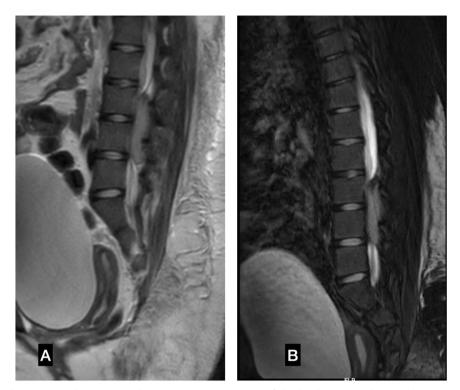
Radiographic findings. Sagittal T2W (A) and mDixon (B) MRI images of the lumbar spine showing hypointense lesion at L3-L4 level causing significant canal compromise.
